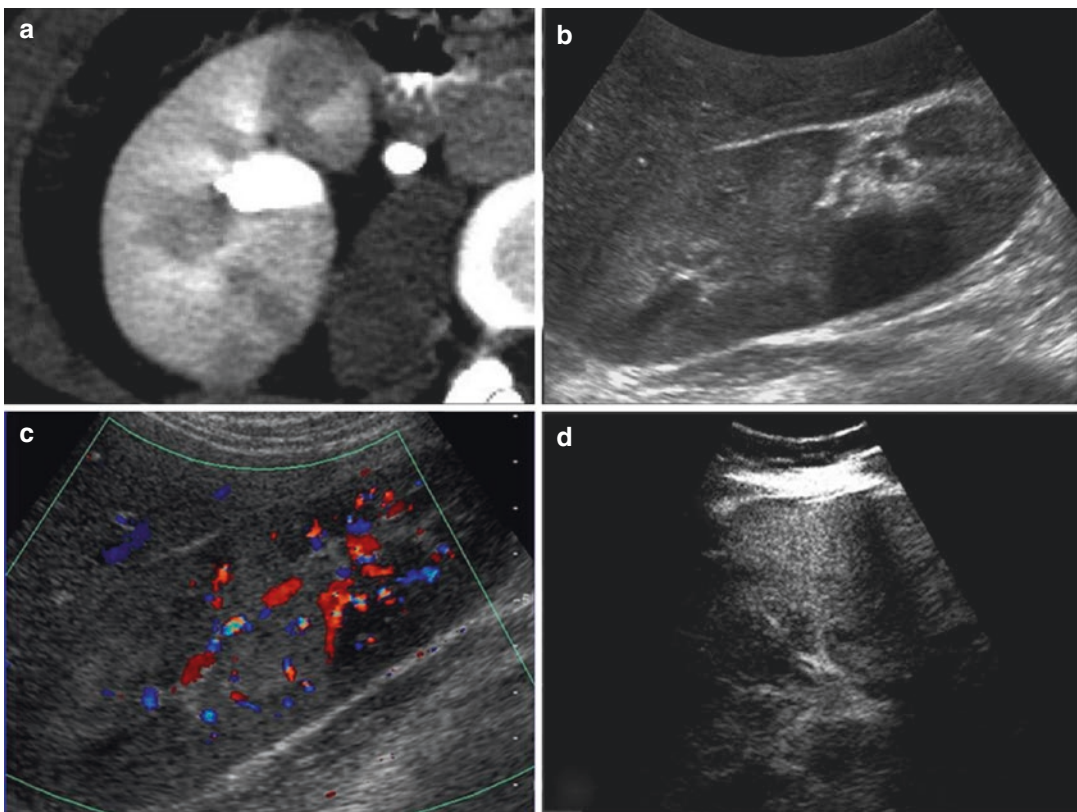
Contrast-enhancement CT shows an inhomogeneous parenchymal enhancement (a). Baseline US (b) demonstrates a wedge-shaped ipoechoic area with poor vascularisation on colour Doppler evaluation (c). CEUS confirms the lack of contrast enhancement in this area (d)
